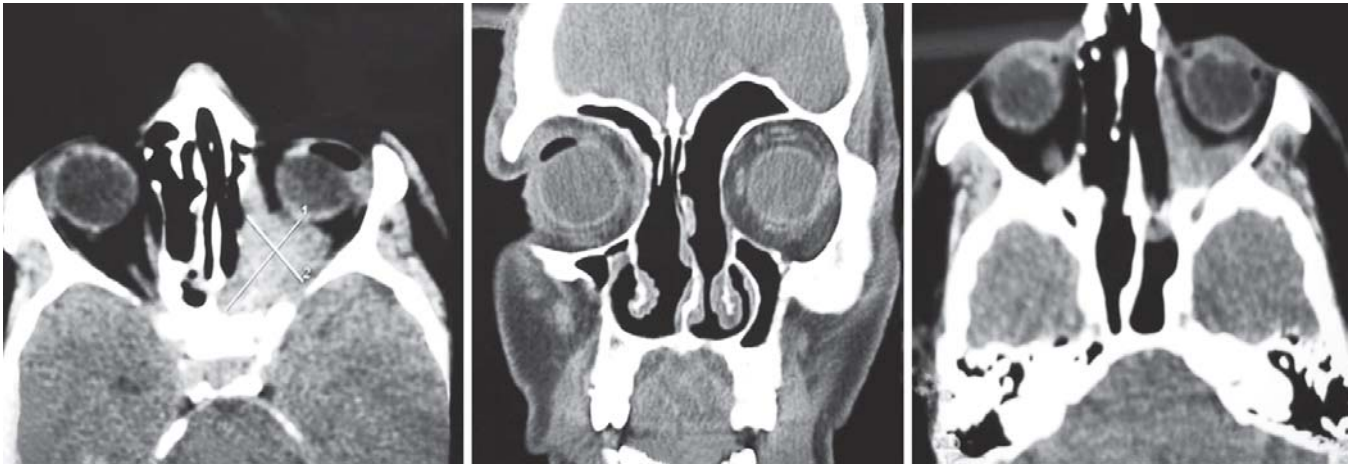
CT scan nose, PNS, orbits (axial and coronal sections) showing chronic invasive sinus aspergillosis postdebridement and 3 months posttreatment with voriconazole
